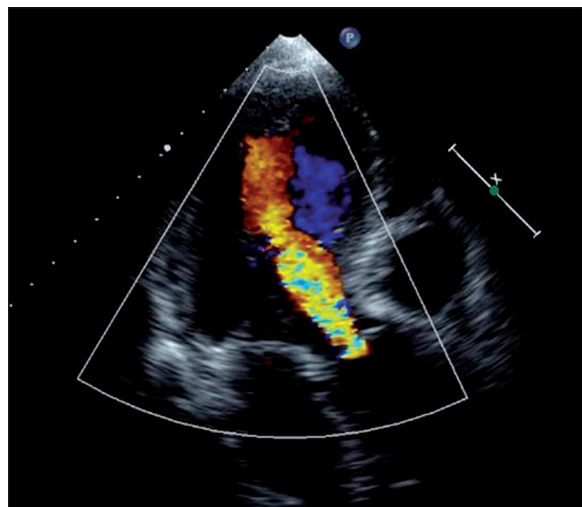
Apical long-axis view of left ventricle in 2-dimensional transthoracic echocardiography, which demonstrates severe aortic valve regurgitation.
